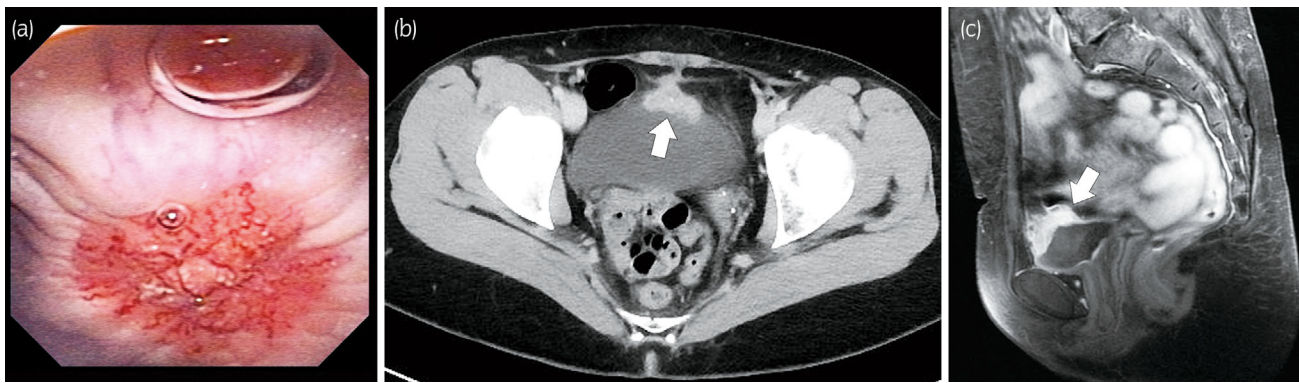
Cystoscopy revealed a bulging submucosal tumor with central telangiectasia (a). CT scan (b) and post-contrast magnetic resonance imaging (c) showed a mass lesion at the bladder dome extending toward the umbilical ligament (white arrow), suggesting extraserosal invasion.
